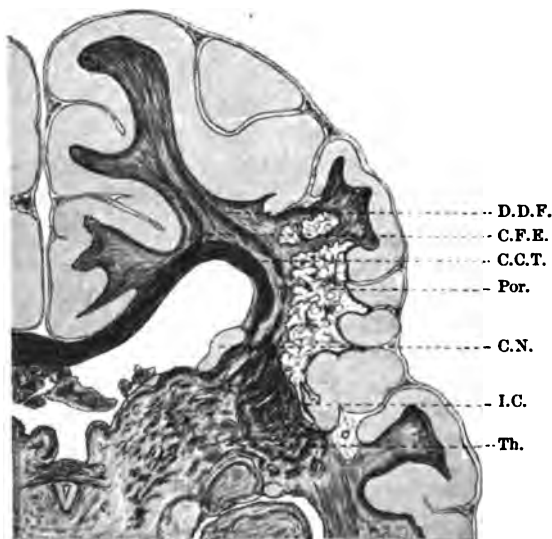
PORENCEPHALIA AFFECTING LATERAL ASPECT OF CEREBRUM (Natural Size).
